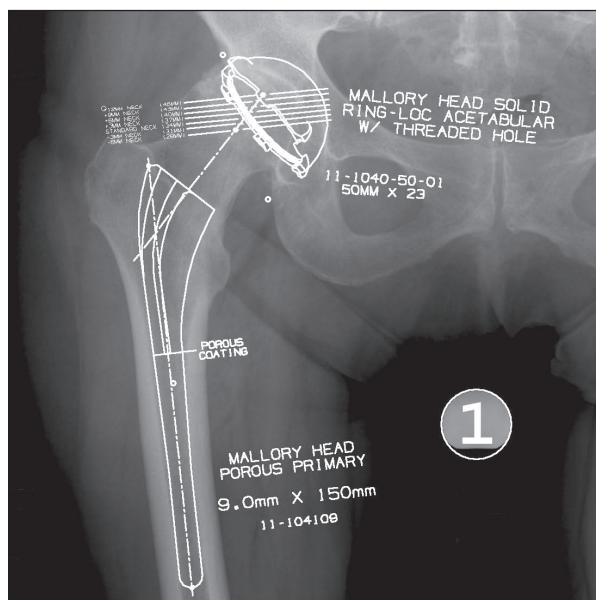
Plain pelvic radiograph with calibration object (1) placed between the patient's legs at the estimated anteroposterior level of the hip joint. The cobalt chromium calibration object has a known diameter of 28 mm and is used to adjust the magnification of the digital templates to the magnification factor of the radiograph.
